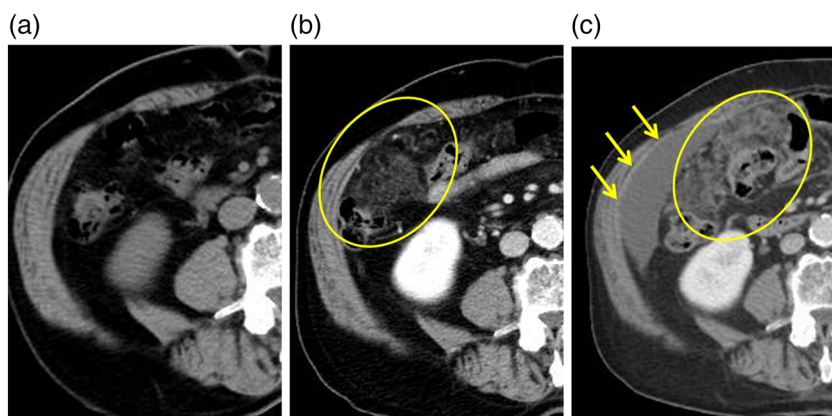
The time course of the abdominal computed tomography findings suggest that peritoneal dissemination was progressing slowly. (a) In May 2012, high-density lesions in the intestine were not observed before chemotherapy. (b) In November 2013, the patient was receiving bevacizumab, and 2 months before the onset of appendicitis, high-density lesions in the intestine (inside the yellow line) and small ascites (not shown) were observed. (c) In August 2014, 7 months after the onset of appendicitis, high-density lesions in the intestine (inside the yellow line) and the ascites (yellow indicator) were increased.
